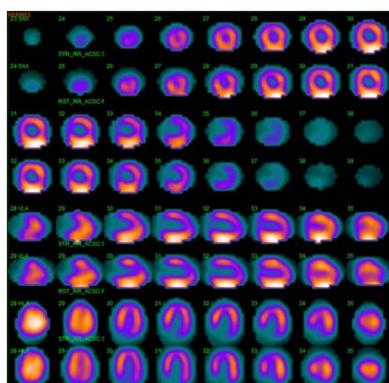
^{99m}Tc-sestamibi single-photon emission computed tomography scintigraphy, demonstrating normal myocardial perfusion and a normal left ventricular ejection fraction.
